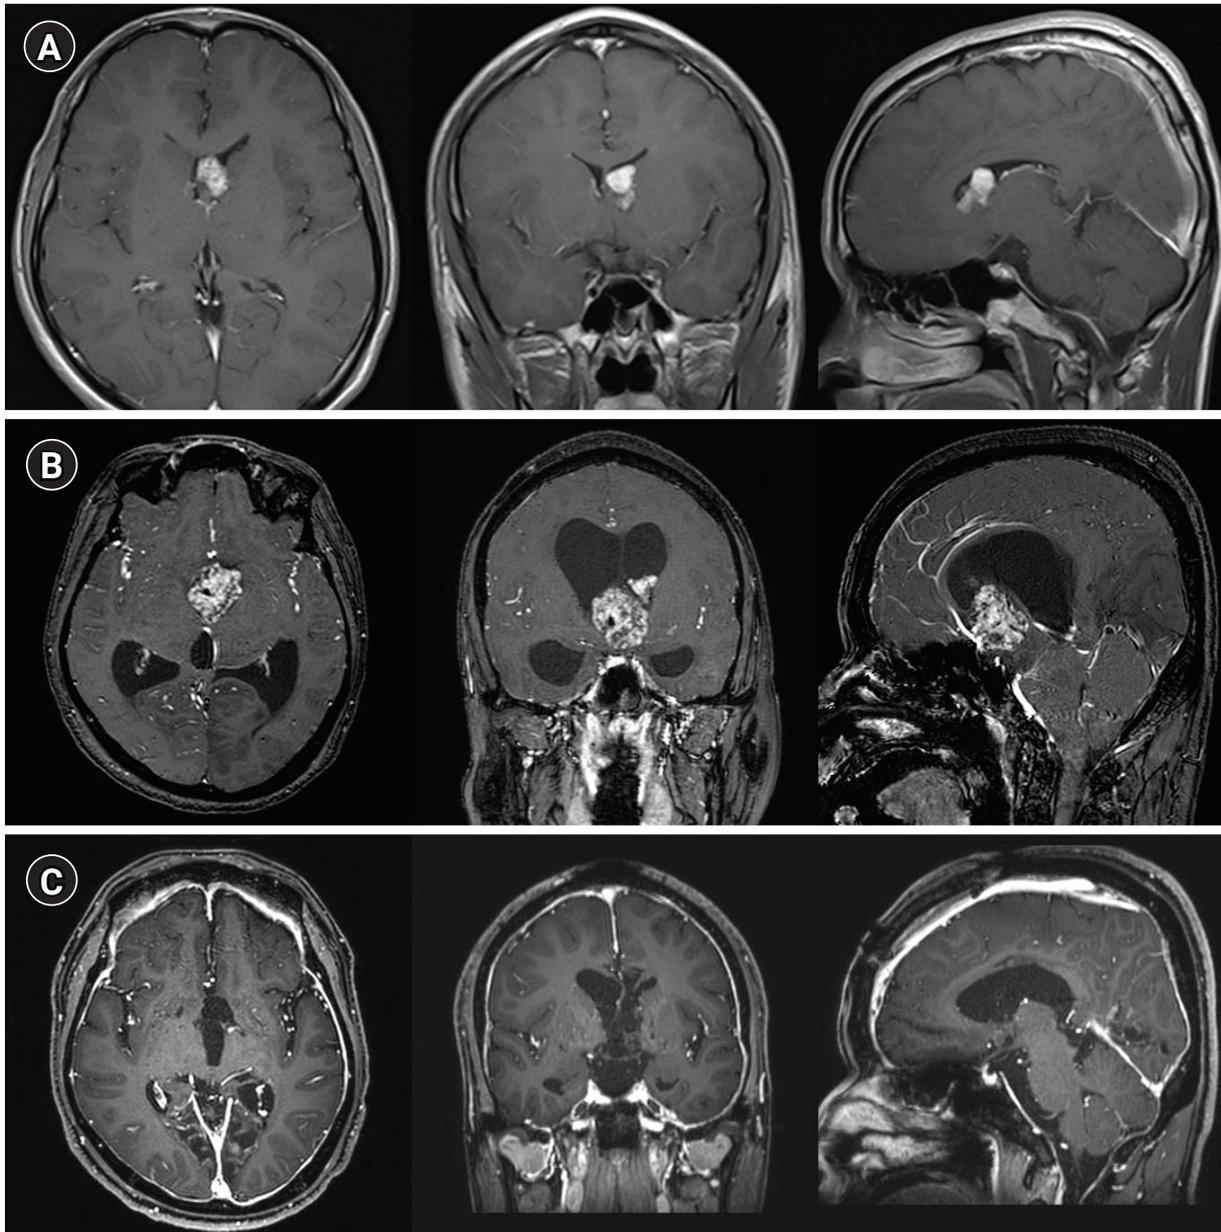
(A) The axial/coronal/sagittal contrast-enhanced T1-weighted sequence from 16 years earlier showed a solid homogeneous lesion in the left lateral ventricle, extending toward the foramen of Monro without hydrocephalus. (B) Immediately preoperatively, the contrast-enhanced T1-weighted sequence showed marked heterogeneous enhancement and proximal aqueduct occlusion with marked hydrocephalus. Coronal and sagittal magnetic resonance imaging images showed marked dilatation of the lateral and third ventricles, with a normal-sized fourth ventricle. Note the downward bowing of the third ventricle floor with expanded infundibular and optic recesses. (C) Postoperative contrast-enhanced T1 axial scans showed no residual tumor with marked meningeal enhancement.
